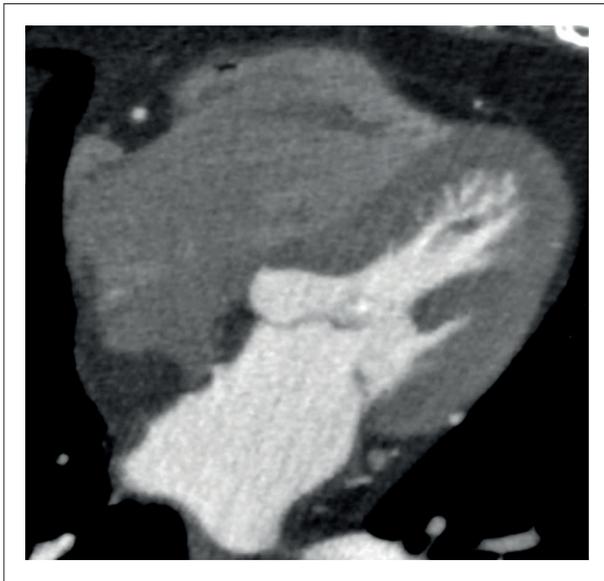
A 70-year-old female patient undergoing coronary tomography angiography for evaluation of chest pain. Axial reformatted CT images demonstrate an incidental finding of lipomatous hypertrophy of the interatrial septum. Note that the infiltrative adipose tissue spares the topography of the fossa ovalis, a typical feature of this finding.
